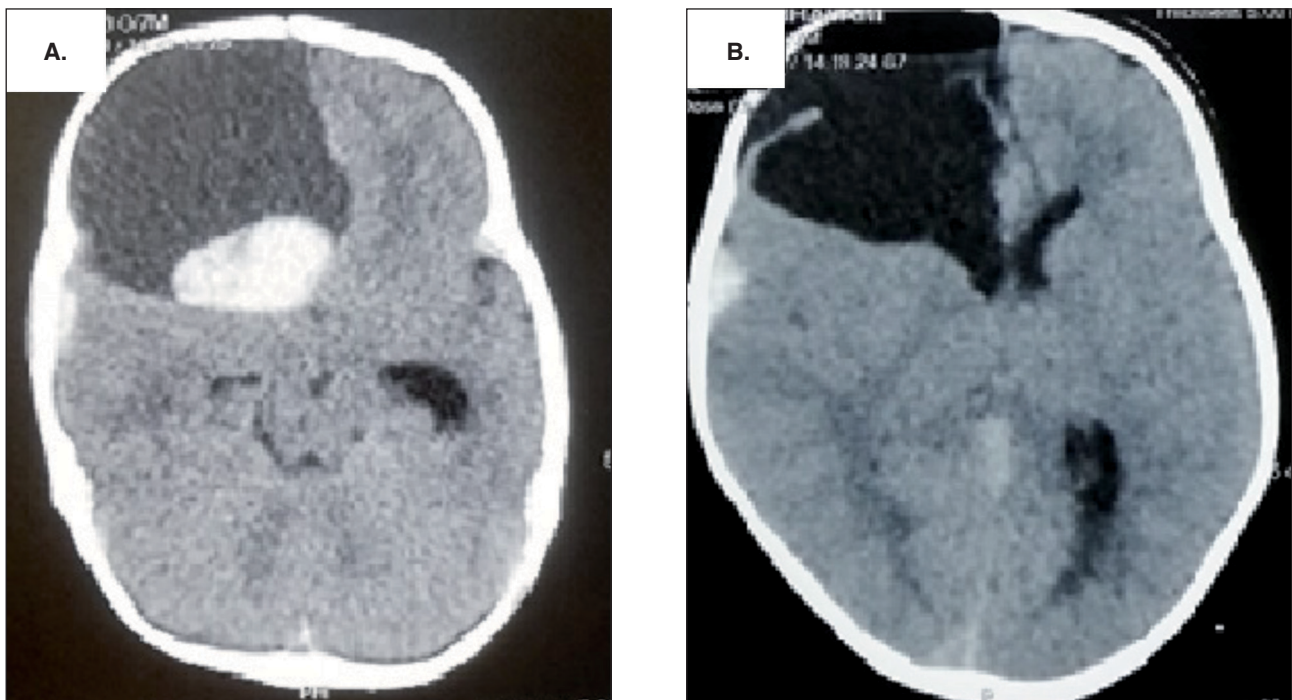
Computed tomography (CT) scans. A. Emergency CT scan prior to surgery showed an atypical large hematoma in the right frontal region, with multiple loculations containing altered blood of different signal intensities, suggestive of recurrent bleeds over a long time, with incomplete resolution and membrane formation. B. Post-operative CT scan was suggestive of decompressed intracerebral hemorrhage and reduced mass effect.
